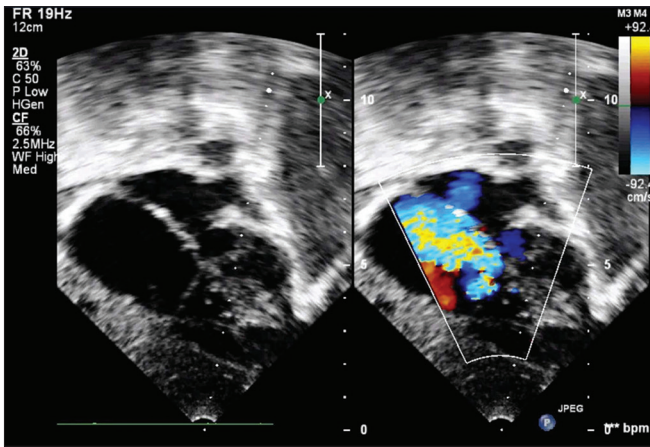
Transthoracic echocardiogram (subcostal window) showing tiny residual VSD with large right to left shunt across VSD and PFO, with severe TR
